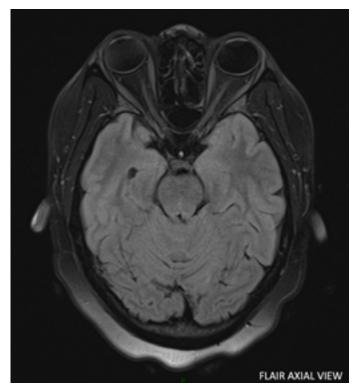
MRI axial FLAIR also demonstrating CSF filled pituitary fossa.
